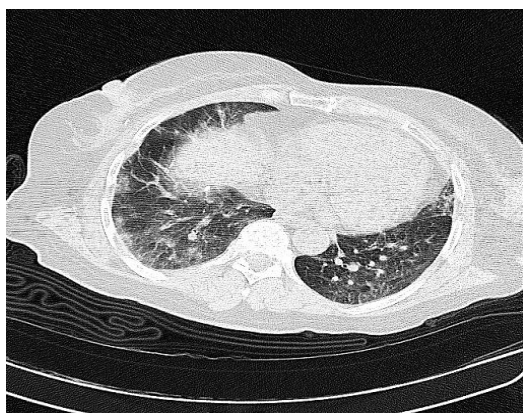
Case No. 1: computed tomography (CT) scan showing bilateral multi-lobar ground-glass opacities (GGOs) in the peripheral zone suggesting coronavirus disease 2019 (COVID-19)
